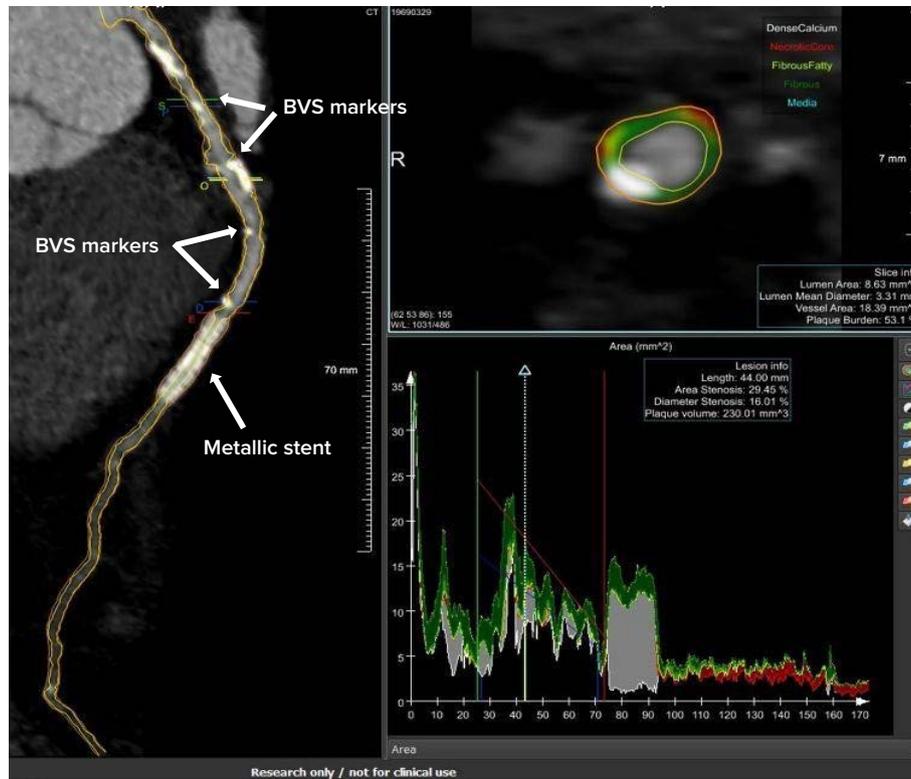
CTA of the left anterior descending artery at 12 months after PTCA with 3 BVS and 1 DES – QAngio-CT RE post-processing software (Medis, Leiden, the Netherlands)
